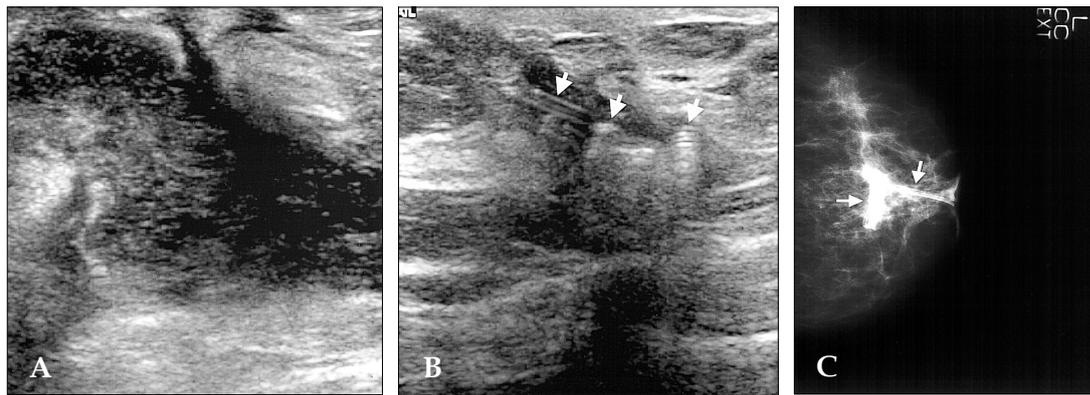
A 44-year-old woman, who had received treatment for a breast abscess 6 months prior, complained of a painful mass in the subareolar area of the left breast. (A) Initial ultrasonogram of the subareolar area of the left breast shows an ill-defined, inhomogeneous, hypoechoic lesion with internal, free-floating debris, which is highly suggestive of an abscess cavity. (B) Follow-up ultrasonogram of a palpable mass after incision and drainage shows an ill-defined, hypoechoic lesion with internal echogenic parallel lines having a reverberation artifact, suggesting a foreign body (arrows). (C) Craniocaudal mammogram reveals a silastic drain in the left subareolar area (arrows).
